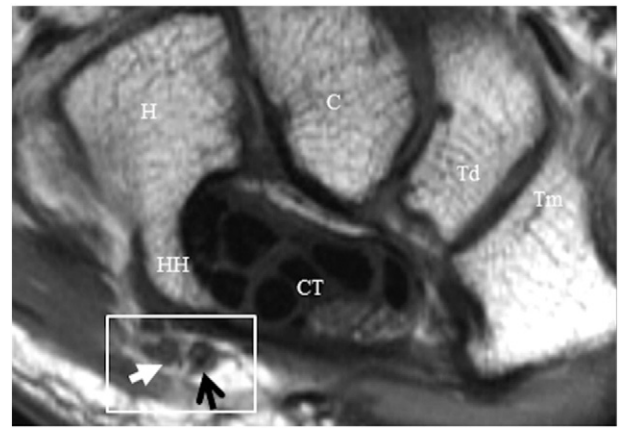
MR anatomy of Guyon's canal. Axial T1 of the wrist at the level of the hook of hamate. Hook of hamate (HH), carpal tunnel (CT), hamate (H), capitate (C), trapezoid (Td), trapezium (Tm), ulnar nerve (white arrow), ulnar artery (black arrow), Guyon's canal (box).
